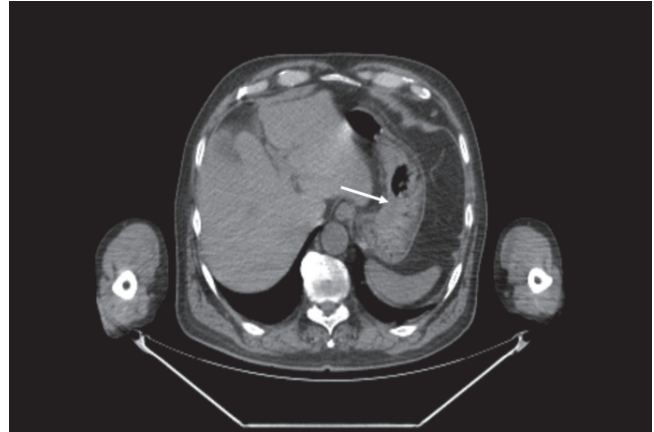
Abdominal computed tomography imaging without contrast. Increased thickness and irregularity in the abdominal wall at the level of the lesser curvature of the stomach (arrow).
